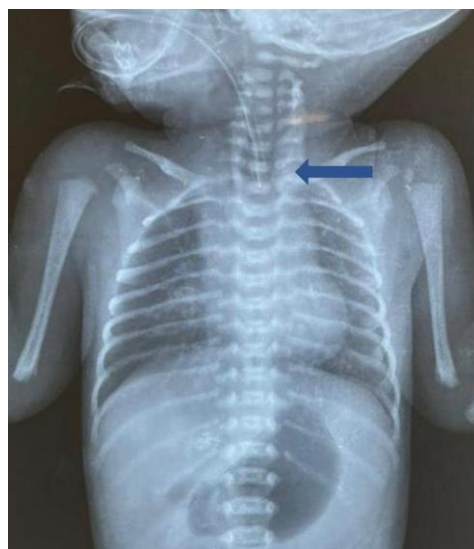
A chest X-ray showed the red rubber catheter in the upper part of esophagus (Marked by an arrow)
